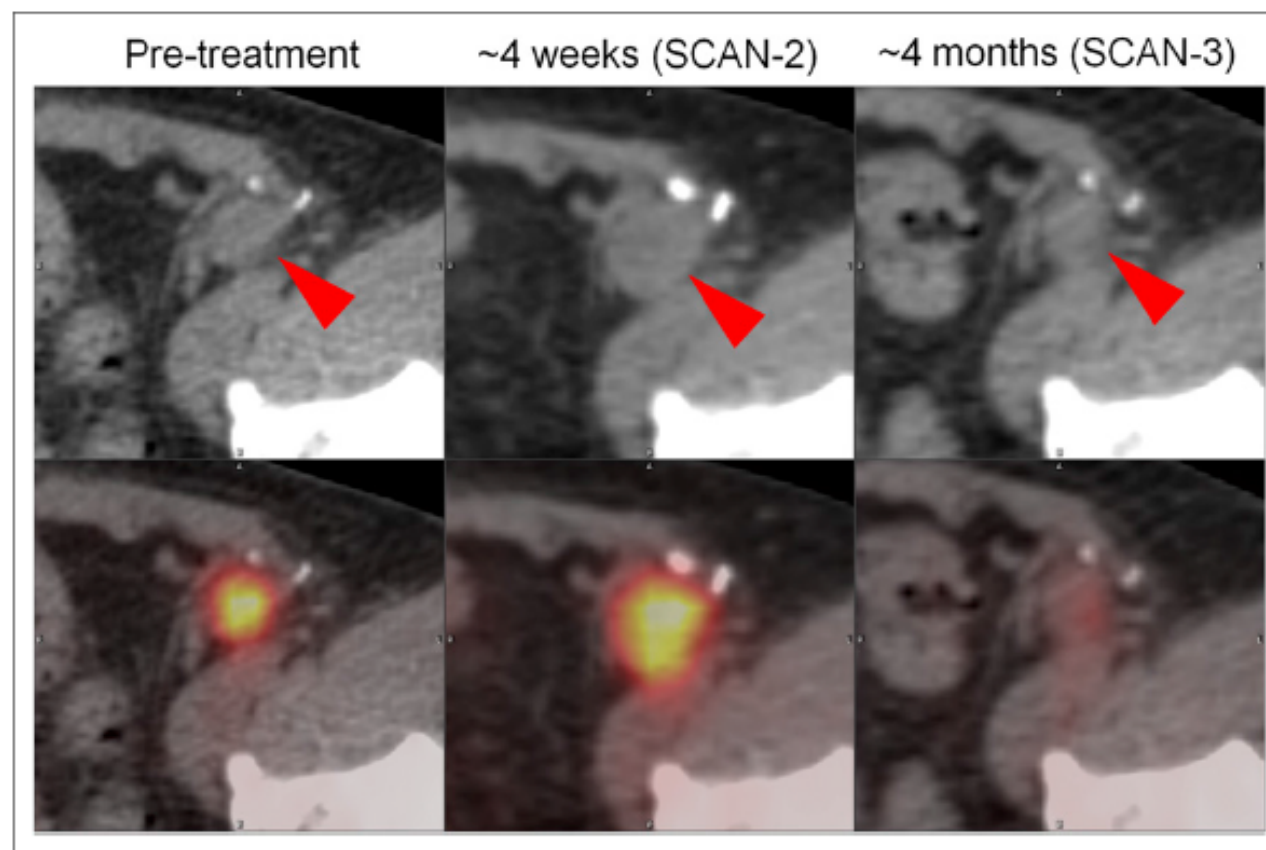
PET/CT images demonstrating representative changes in melanoma inguinal lymph node metastasis (red arrowheads) at 4 wk and 4 mo after initiation of ipilimumab. At about 4 wk
